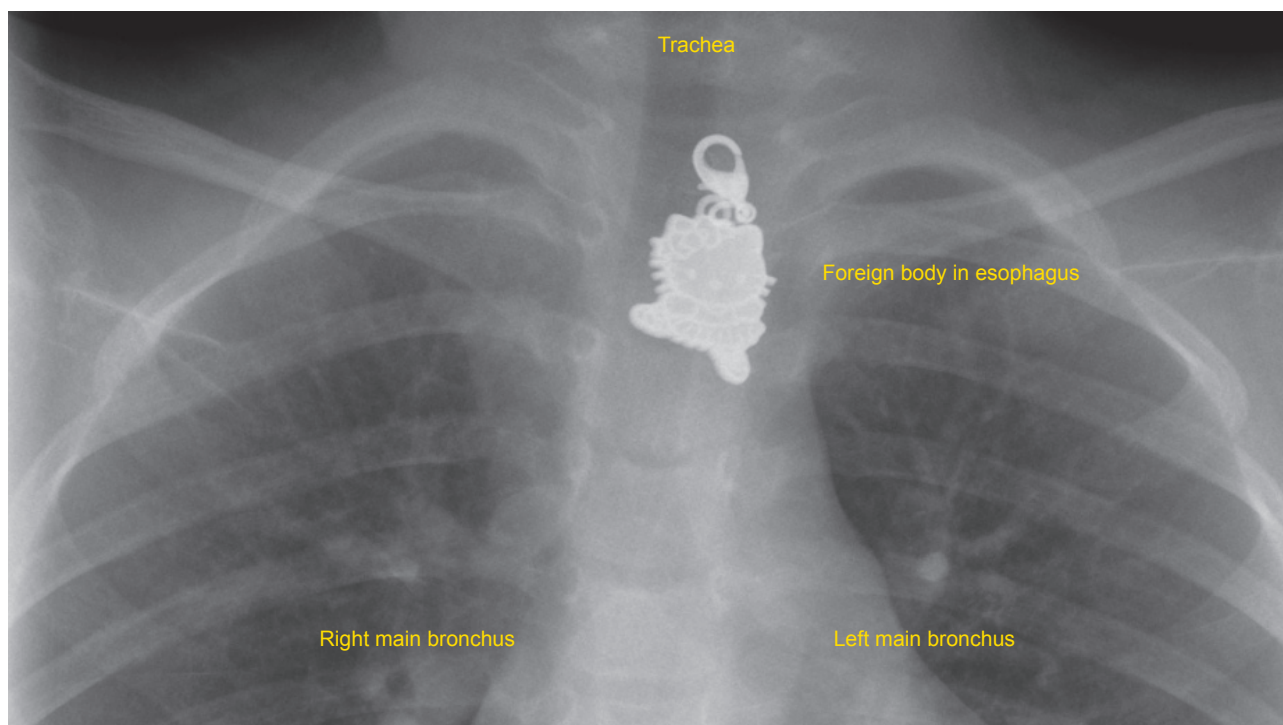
Thorax plain-film radiography showing pendant necklace in the upper third of esophagus
